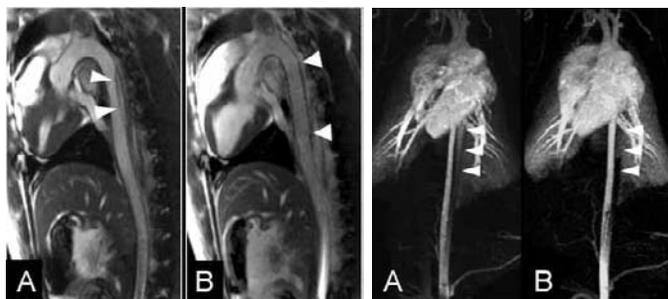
Pre (A) and post-interventional (B) MRI evaluation with TrueFISP retro in parasagittal orientation. (A): Arrowheads show the dissection flap in the proximal descending thoracic aorta. (B): Following stent-graft placement, the false lumen (arrowheads) is completely obliterated. Arrows show the correct position of the stent-graft with complete coverage of the dissection.
